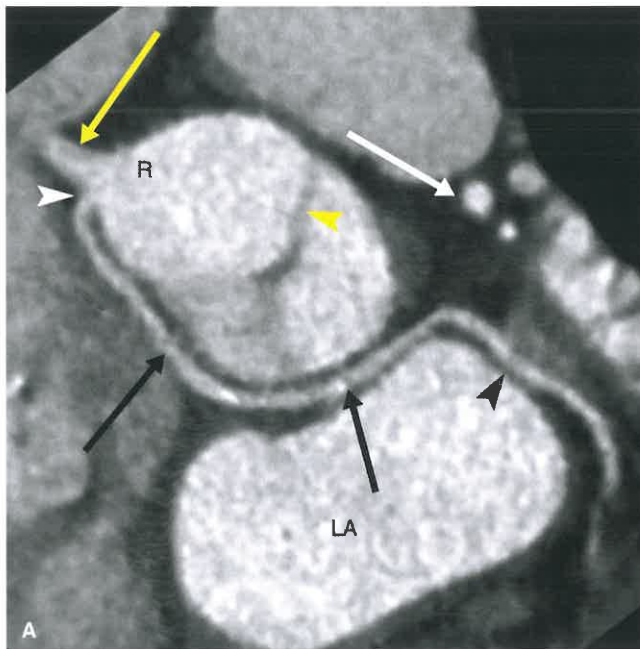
Retroaortic Course. A: Axial oblique image through the aortic root from a coronary CTA in a 47-year-old man shows that the origin of the LCx (white arrowhead) is from the right coronary sinus (R). The LCx then courses posteriorly (black arrows) between the aortic root and left atrium (LA) before entering its normal territory (black arrowheads). The LCx has a separate ostium from the RCA (yellow arrow). The LAD (white arrow) originated from the left coronary sinus. Incidental note is made of a bicuspid aortic valve (yellow arrowhead). B: Sagittal oblique image from a coronary CTA in a 9-year-old child shows ostium of the RCA (black arrow) arising from the left sinus (L) and coursing posteriorly between the left atrium and aortic root (black arrowhead) before entering the right atrioventricular groove (yellow arrow). While the LCx anomaly is not uncommon, a retroaortic course of the RCA is extremely rare. Both are benign courses.
